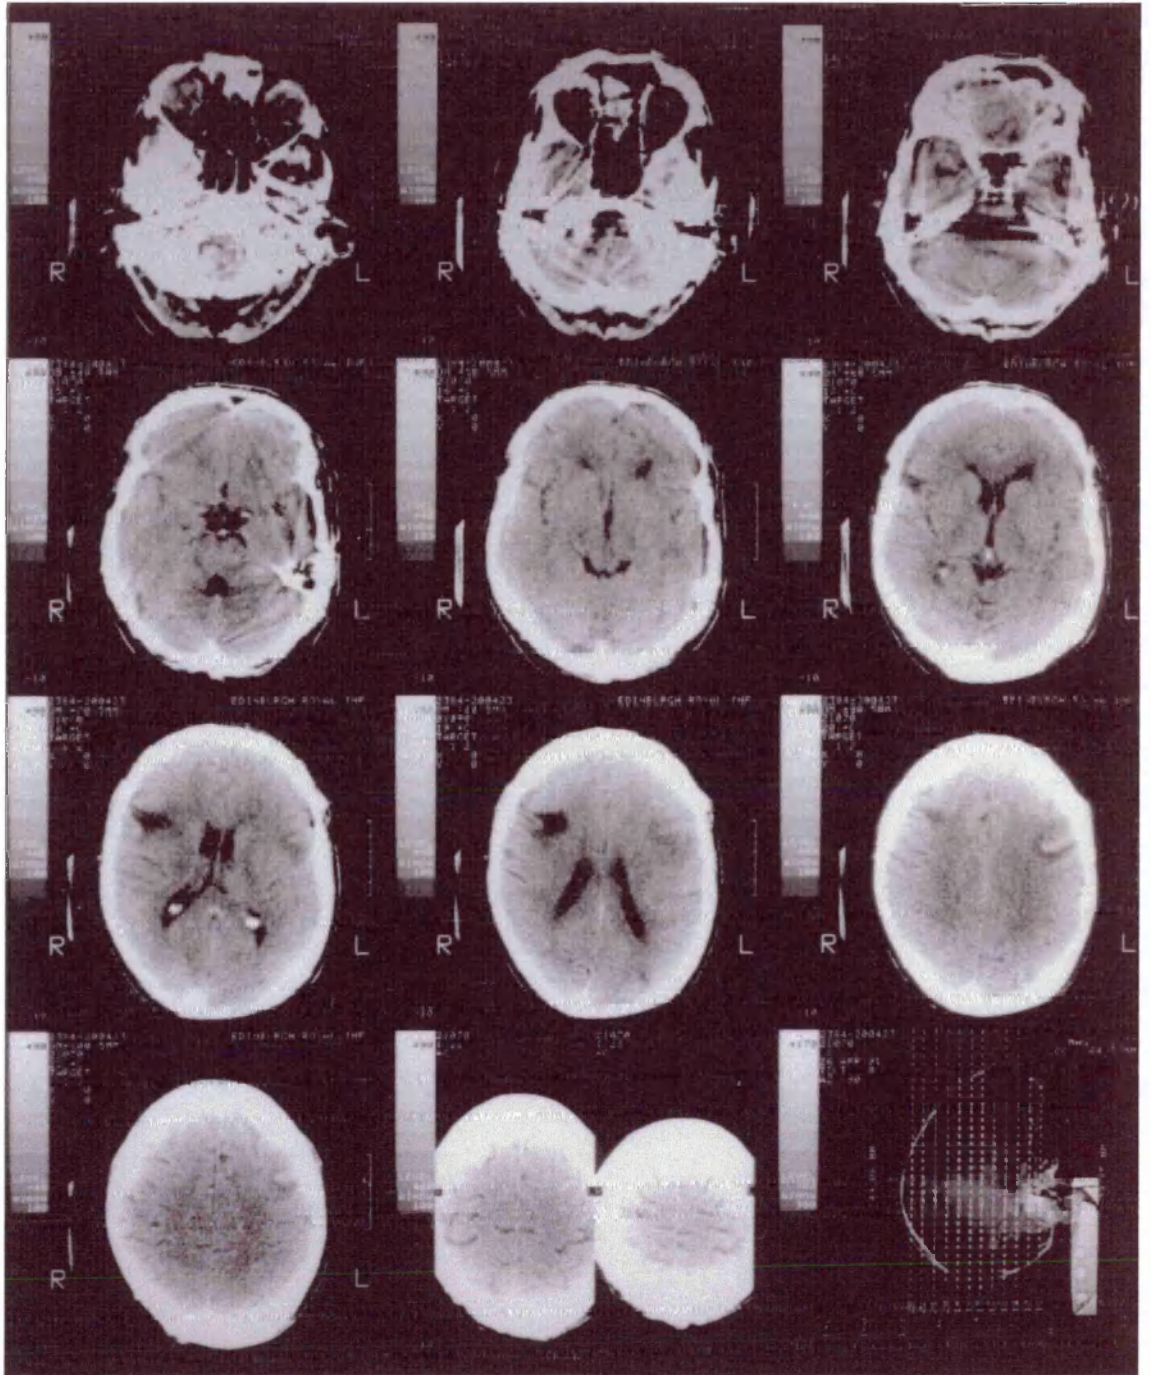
CT scan for HL.
